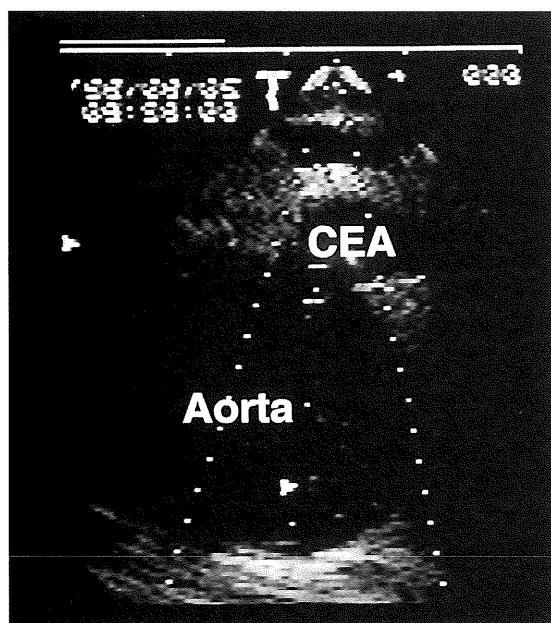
Echogram (transverse scan) of the celiac artery (CEA) arising from the aorta from the 1 o'clock position. An upward and leftward flexion of the probe is applied for visualizing the CEA. It divides into branches soon after. The bright area in the lumen indicates the blood flow in color Doppler mode.
